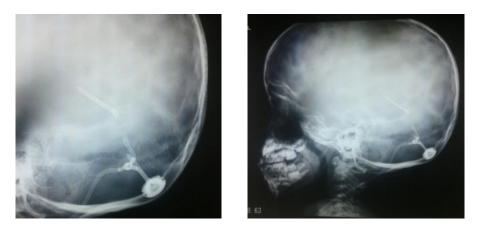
Plain X-Ray show: Y connected VP + CP Shunt
